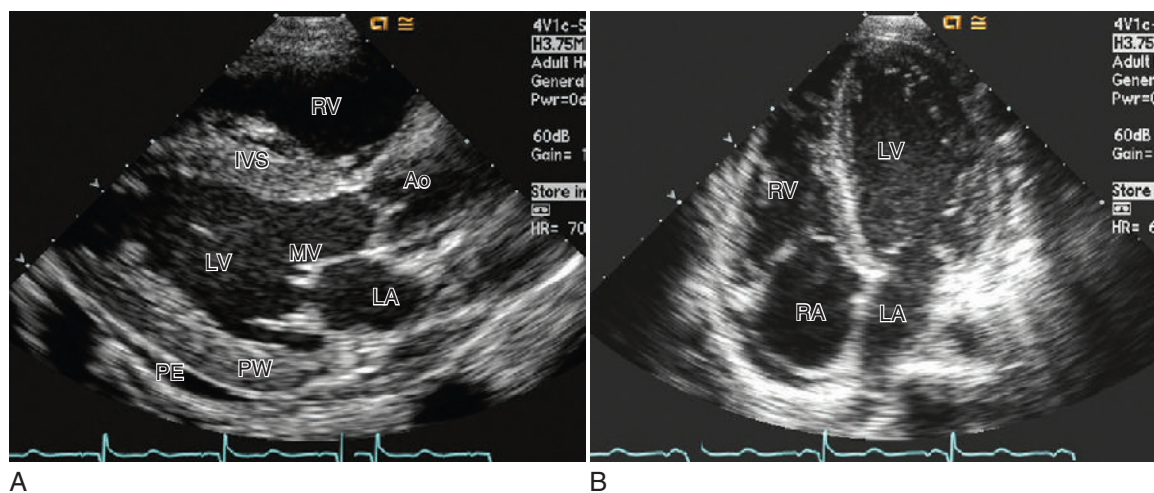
Portions of standard two-dimensional echocardiograms show the major cardiac structures in a parasternal long-axis view (A) and apical four-chamber view (B). Video 4-3 shows a moving image of a two-dimensional echocardiogram. Ao, Aorta; IVS, interventricular septum; LA, left atrium; LV, left ventricle; MV, mitral valve; PE, pericardial effusion; PW, posterior left ventricular wall; RV, right ventricle. (Image courtesy Sheldon E. Litwin, MD, Division of Cardiology, University of Utah, Salt Lake City, Utah.)
